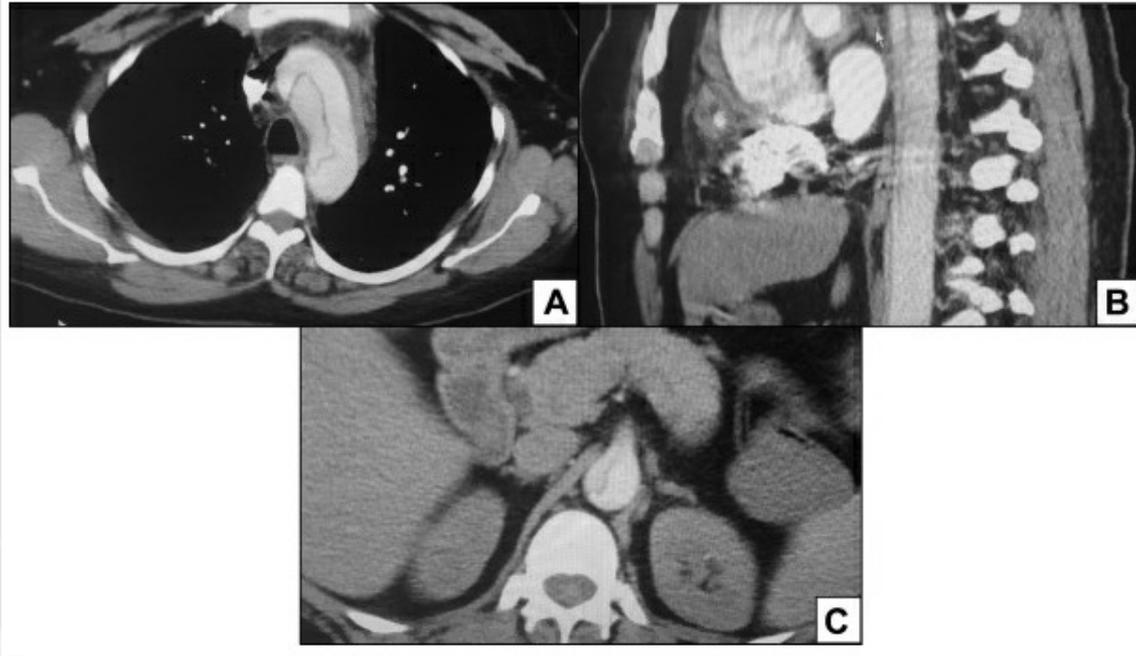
Computed tomography angiography (CTA) imaging on initial assessment of the patient. A, Dissection in the aortic arch. B, Severely narrowed true lumen in the descending thoracic aorta (coronal). C, Dissection extending into the superior mesenteric artery (SMA).
